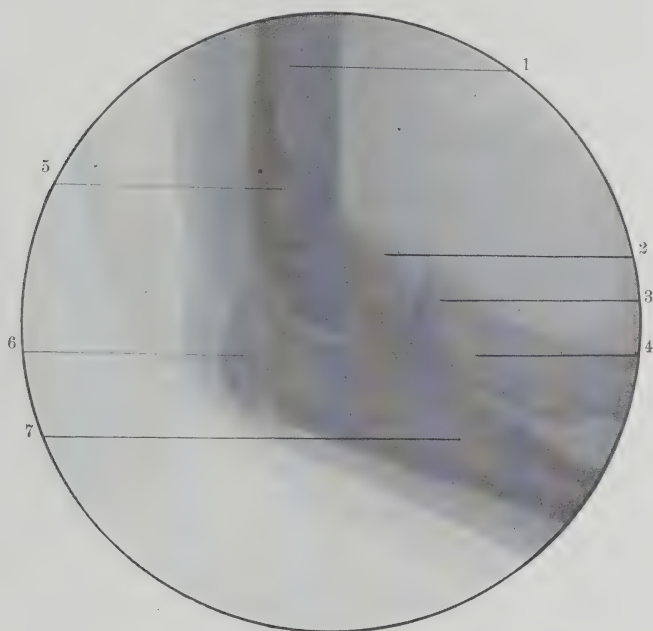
Radiograph Showing Lateral View of Elbow at Fifteen Years. 1, Humerus; 2, capitellum; 3, upper epiphysis of radius; 4, radius; 5, compact tissue of the lower end of humerus; 6, epiphysis of olecranon partial joint; 7, ulna. (Original.)
